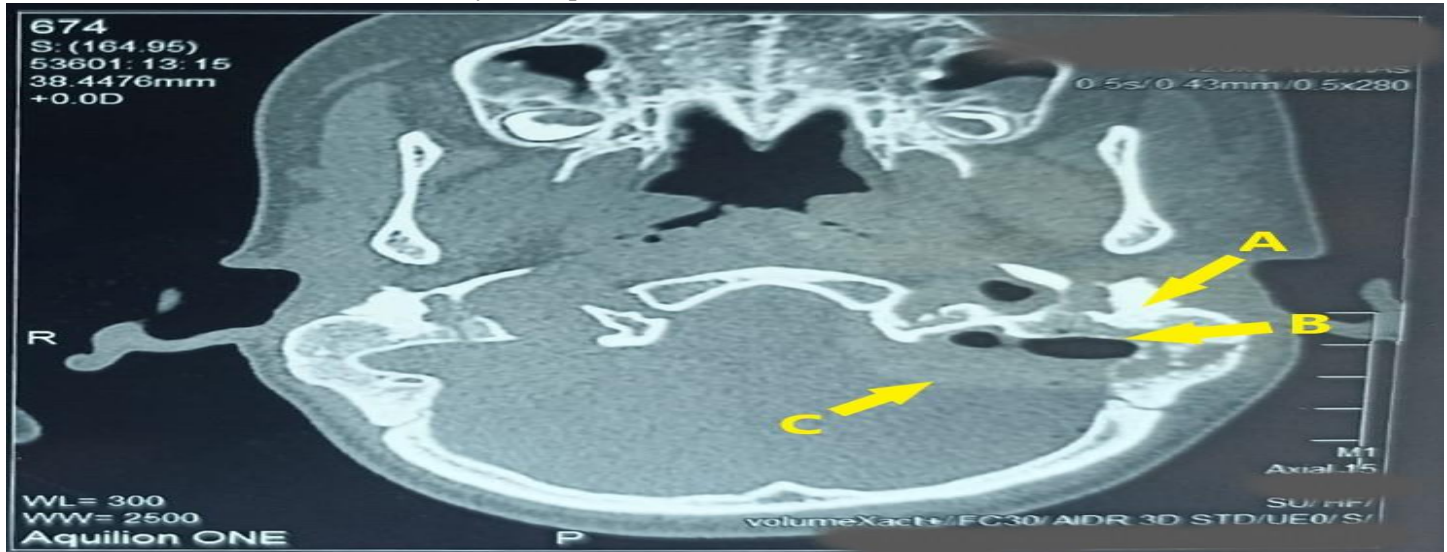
Cerebellar Abscess: CT Temporal Bone with IV Contrast Axial view. Hypo pneumatization, massive osseous erosion, and sclerosis of left middle ear cavity and left mastoid cavity (A), resulting in the fistulous tract formation between the middle ear cavity and posterior cranial fossa (B) resulting in left cerebellar abscess (C). MRI Brain of the patient was also performed, showed peripheral ring enhancing lesion in the left cerebellar hemisphere with necrotic center, mild ventriculitis, and less well-defined rim.
